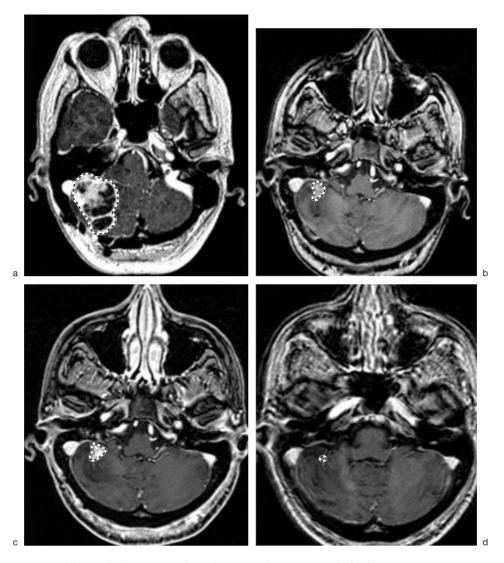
T1 weighted, contrast enhanced, transaxial MR images highlighting a metastatic tumour from a melanoma primary. (a) Pre-treatment scan, tumour volume = 17cc; (b) 5 months after radiosurgery, tumour volume = 1.0cc; (c) 12 months post radiosurgery, tumour volume = 1.0cc; (d) 15 months post radiosurgery, tumour volume = 0.756cc. Follow up at 21 months post radiosurgery showed further tumour reduction to 0.185cc. (The patient died 24 months after SRS as a result of progressive systemic disease.) (Images courtesy of the Cromwell Hospitals Gamma Knife Centre.)
